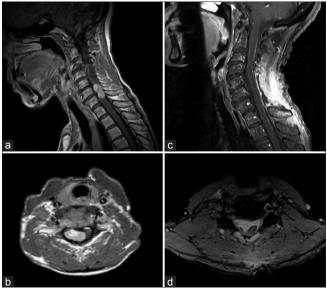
Pre- and post-operative magnetic resonance imaging demonstrating solitary fibrous tumor. (a) Preoperative sagittal postcontrast T1 images. (b) Preoperative axial postcontrast T1 images. (c) Postoperative sagittal postcontrast T1 images. (d) Postoperative axial T2 images
